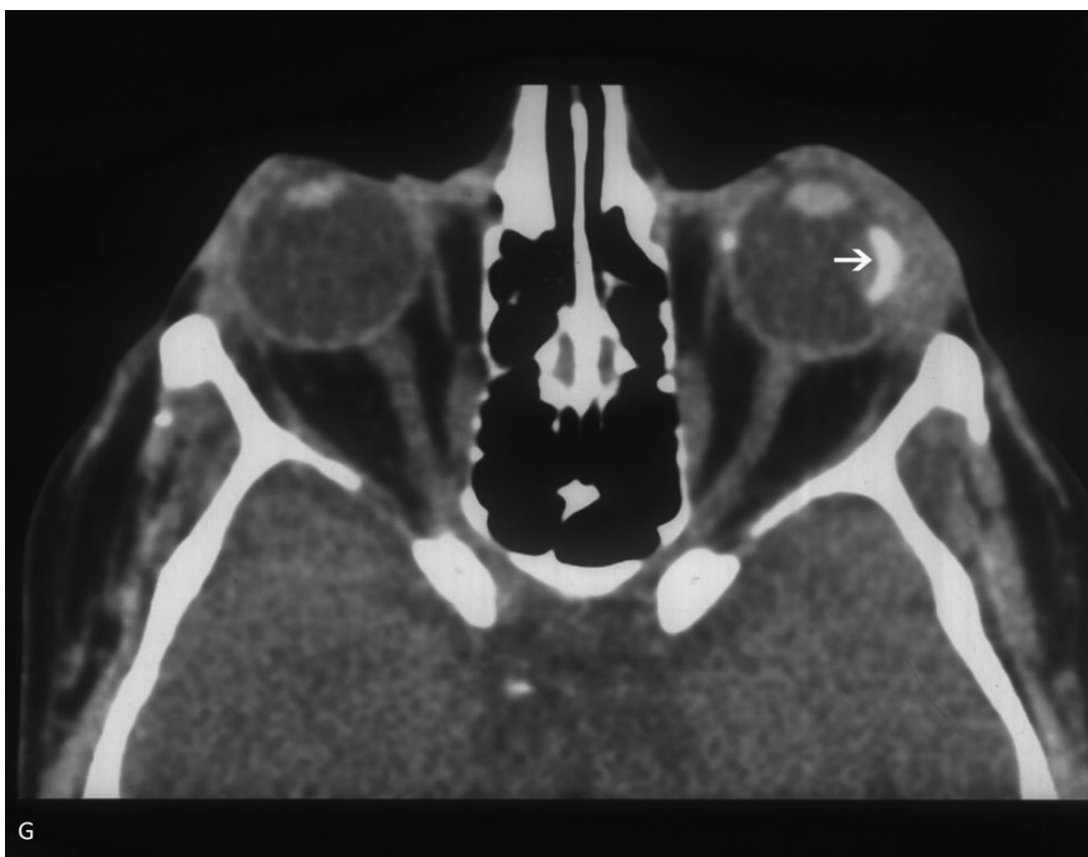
Figure (G) CT scan shows a soft tissue mass around the scleral buckle continuous with the lateral rectus insertion.
